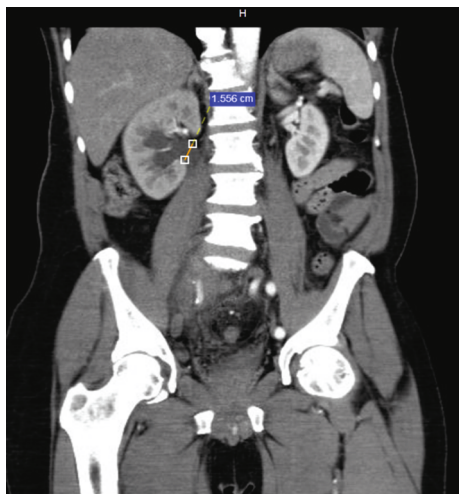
CT-IVU showing the right sided hydronephrosis
